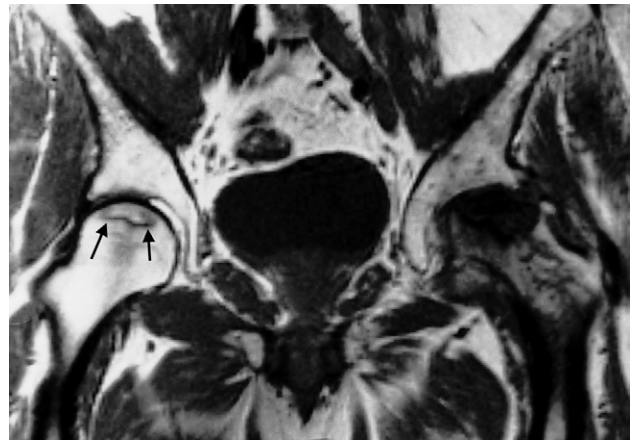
Coronal MRI scan showing avascular necrosis of both femoral heads. The changes on the left are very severe and advanced. The changes in the right hip are relatively early and show a rim of low signal demarcating the ischaemic area (arrows).
